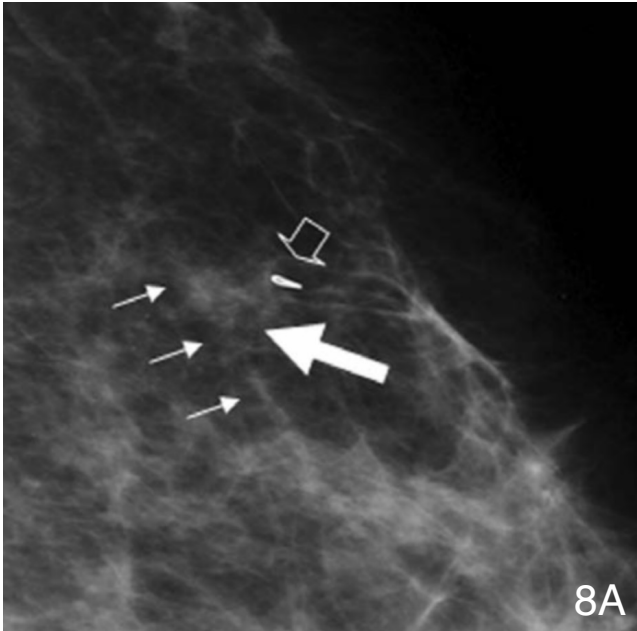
Following ultrasound guided core biopsy; 8A) left MLO (smaller arrows denote an artery for anatomic reference), 8B) CC, and 8C) photographic magnification in the CC projection demonstrate the mass (large solid arrow) and a radioopaque marking clip (large open arrow) placed in the anterior lateral aspect of the tumor.
